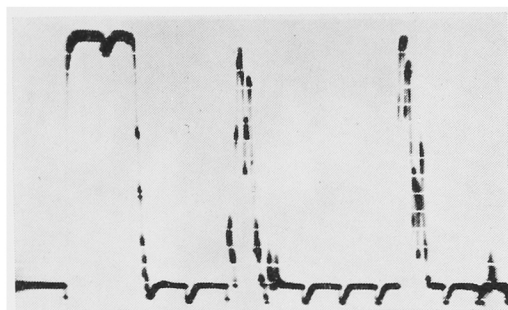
Ultrasono-echogram of Stone (A) Hanging in Water.
